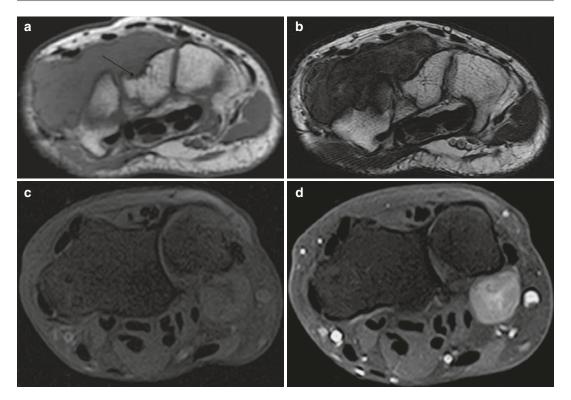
(a–d) Localised nodular synovitis of the wrist in two patients (a–d). (a) Axial T1-weighted MR image. (b) Axial T2-weighted MR image. (c) Axial T1FS pregadolinium. (d) Axial T1FS post-gadolinium. A welldefined soft tissue mass that is of isointense SI to skeletal
